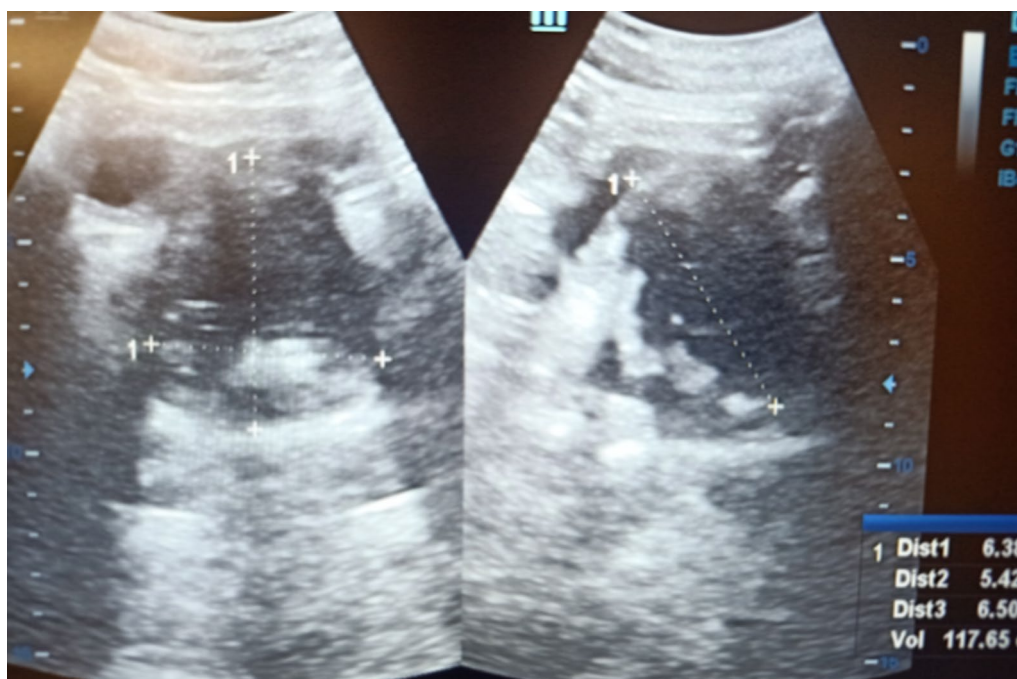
Ultrasound image for prostate volume pre-embolization showing, prostate of estimated volume = 117 g
